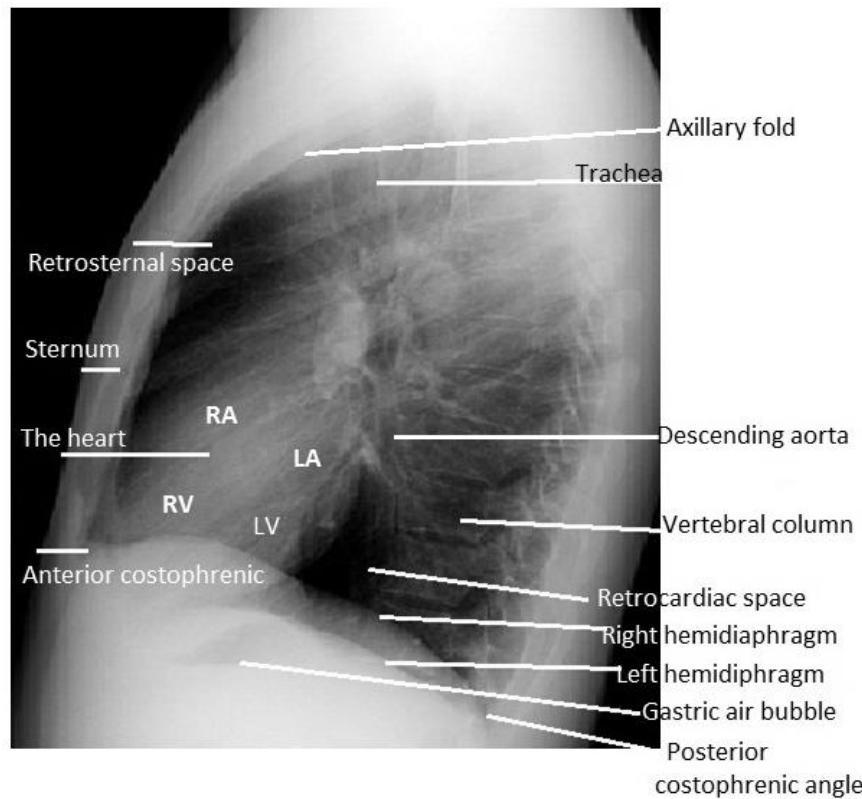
3: Lateral chest radiograph showing the positions of cardiac chambers.
